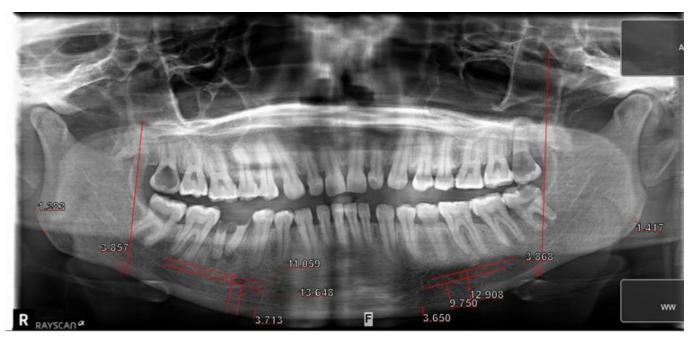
Measuring Radiographic Indices with the RayScan Alpha software
